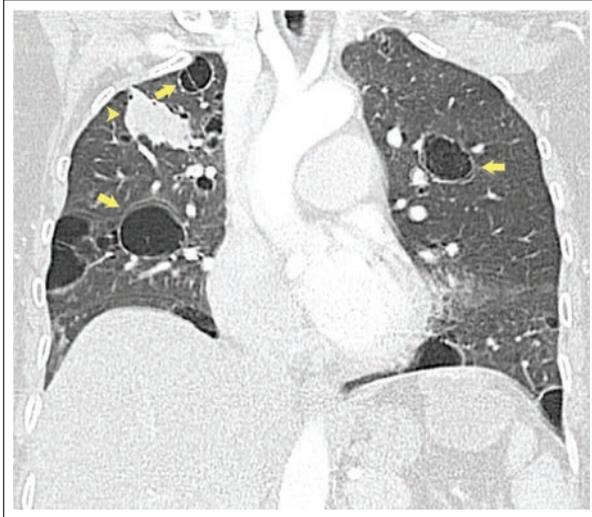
Cystic amyloidosis and amyloidoma. Chest CT coronal reconstruction showing multilobar, bilateral, spherical, thin-walled pulmonary cysts (arrows). Septa in the right apical cyst (arrows). Solid mass in the right upper lobe with lobulated contours corresponding to an amyloidoma (arrowhead).
